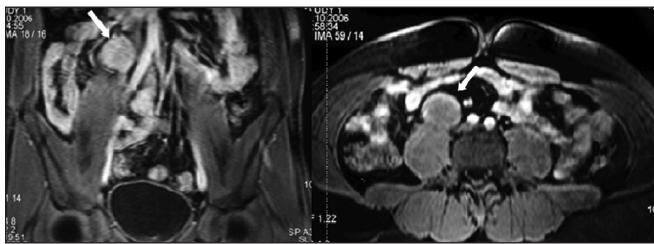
Magnetic resonance imaging scans demonstrating a soft-tissue mass (white arrows) in the right lower quadrant lying on the psoas muscle.
